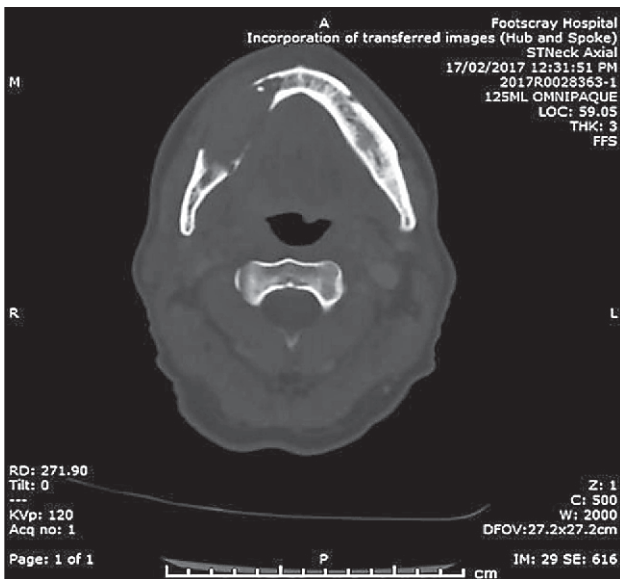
Axial CT of the mandible with bone windows showing cortical destruction of the right body of the mandible. (onlinelibrary.wiley.com)
